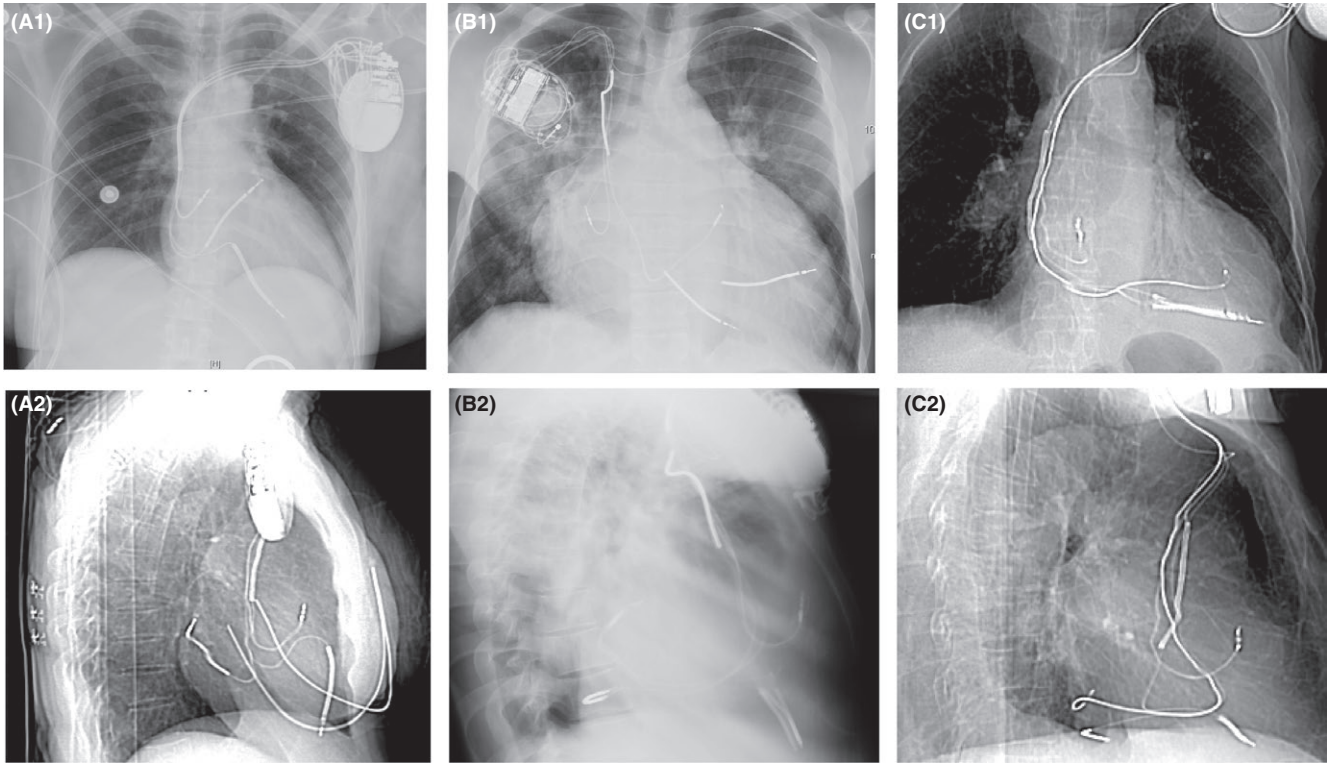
Chest radiograph of cases 1-3, respectively, presented in Table 1, showing the final position of the coronary sinus coil. Postero-anterior fluoroscopic view (A1; B1; C1; D1) and lateral fluoroscopic view (A2; B2; C2; D2)
